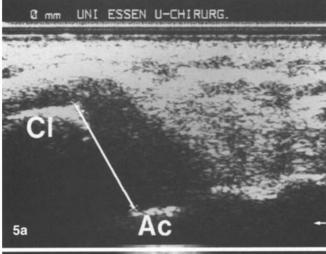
a Ultrasound scan of a patient with Tossy I AC joint injury (7.5-MHz transducer; *Cl* clavicle, *Ac* acromion). The sonographically measured AC joint width is 5.1 mm for the injured left AC joint. b Conventional radiological panorama view of the same patient (*arrow* indicates injured left side)
